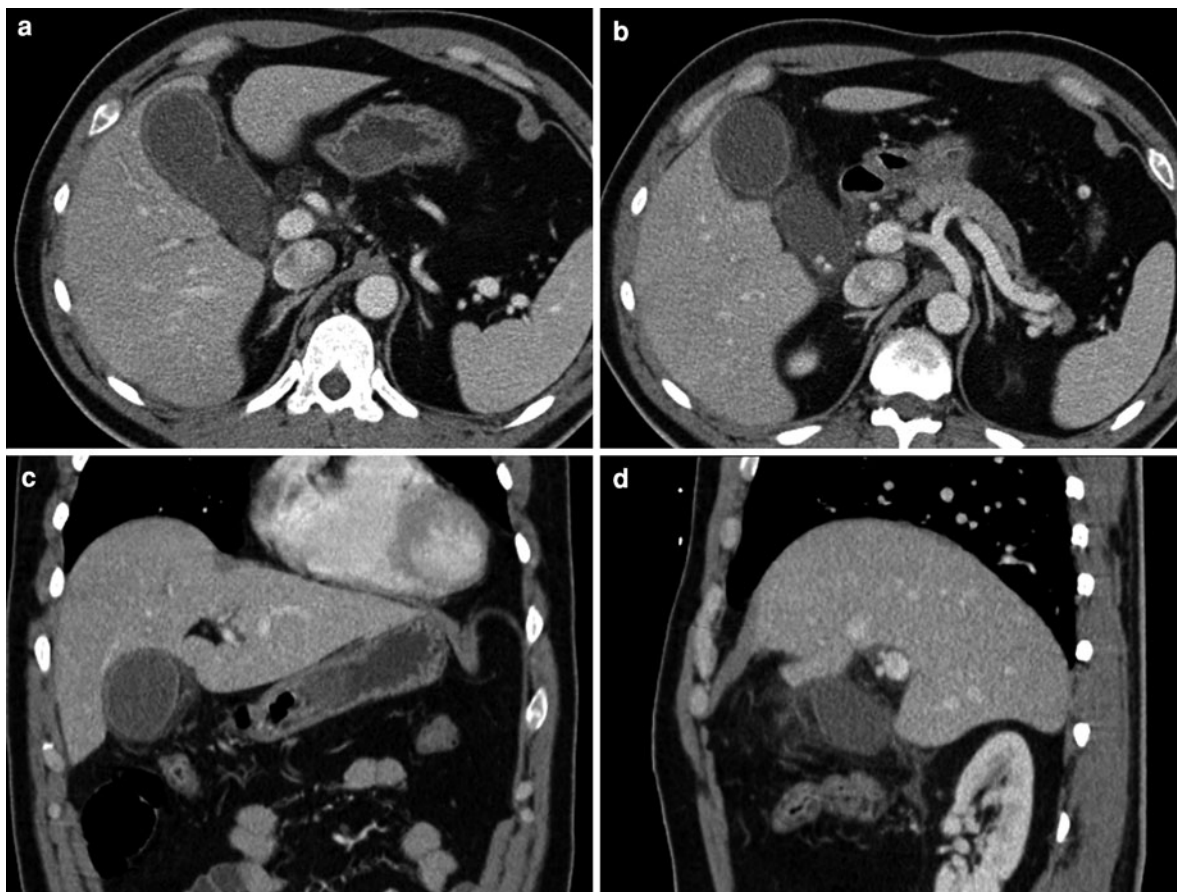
Typical cholecystitis associated with gallstones. A 44-year-old man with right upper quadrant pain, fever, and a Murphy sign. CT in the axial (a, b) coronal (c), and sagittal
